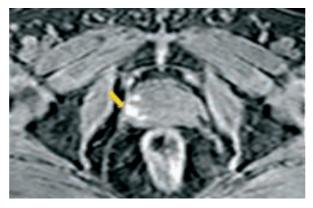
DCE-MRI shows elevated enhancement on the left peripheral zone (arrow). Guided biopsies from this region demonstrated prostate eancer.
